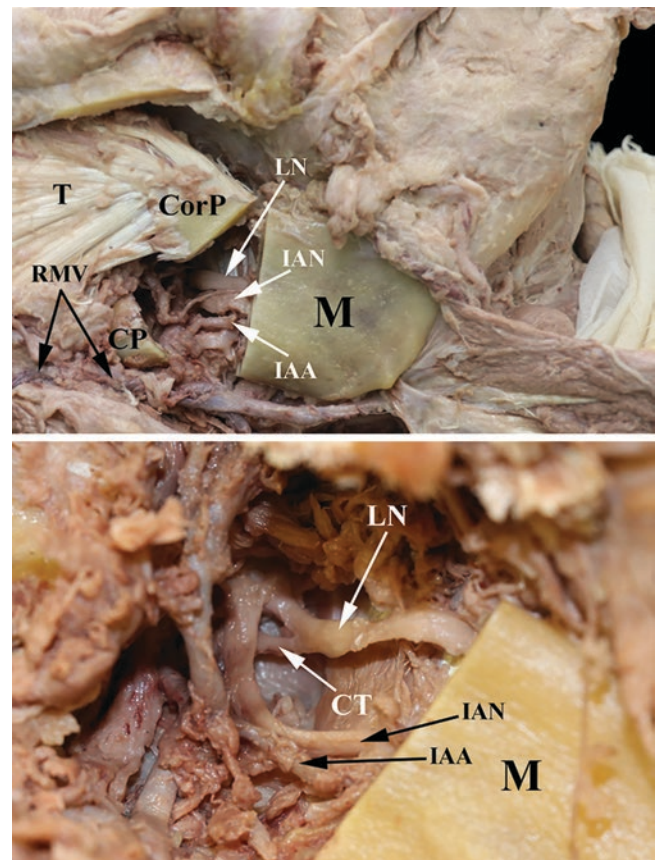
Pathway of the mandibular division of the trigeminal nerve (CN V₃) through the infratemporal fossa. View is from the right side; the middle portion of the ramus of the mandible (M) has been removed. CorP coronoid process, T temporalis muscle, CP condylar process, RMV retromandibular vein, LN lingual nerve, IAN inferior alveolar nerve, IAA inferior alveolar a., and CT chorda tympani
